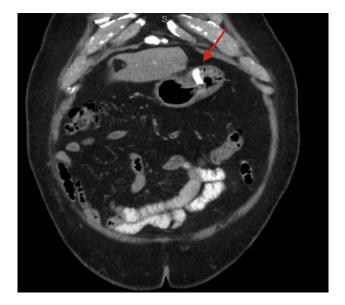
Coronal CT view showing the silastic band partially eroding the gastric lumen.
